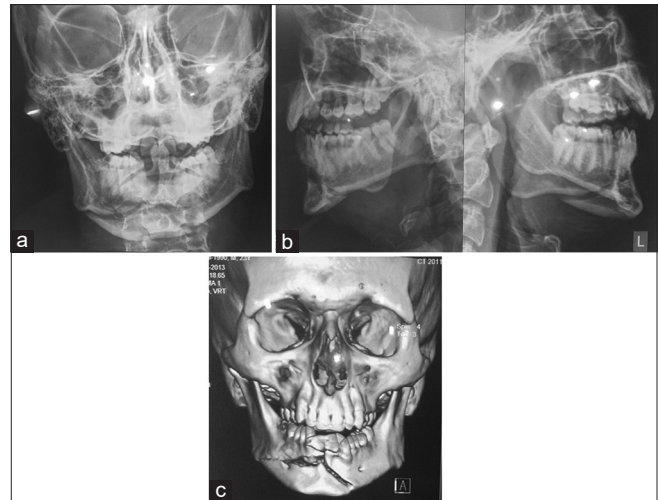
(a) Anteroposterior view of X-ray mandible, (b) three-dimensional computed tomography image showing fracture coronoid process
